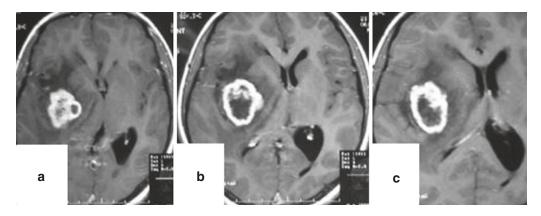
(a-c) Contrast MRI of the brain showing large tuberculoma in right insulo-putaminal area
